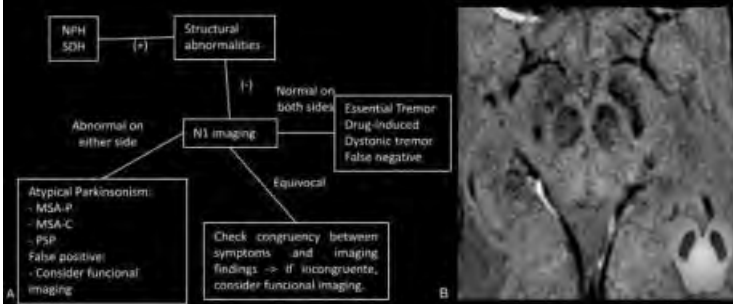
(A) Diagnostic algorithm by using MRI for subjects with parkinsonism. (B) A 52 year-old female with bilateral parkinsonism. Absence of nigrosome-1 hypersignal in SWI.
